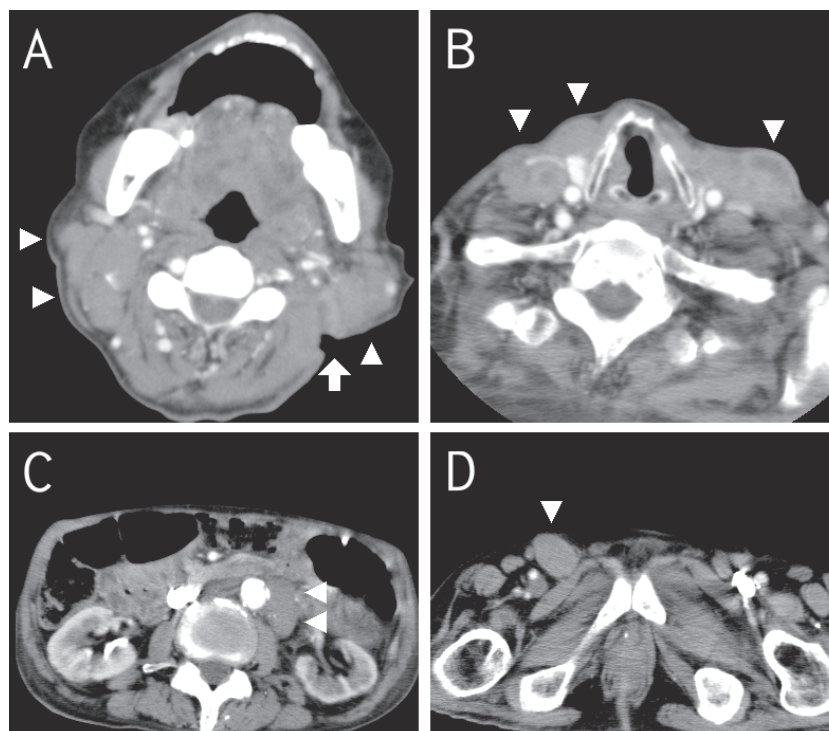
(A, B) Neck computed tomography (CT) revealed large low density mass in the left neck. The arrows indicate the incision site.
